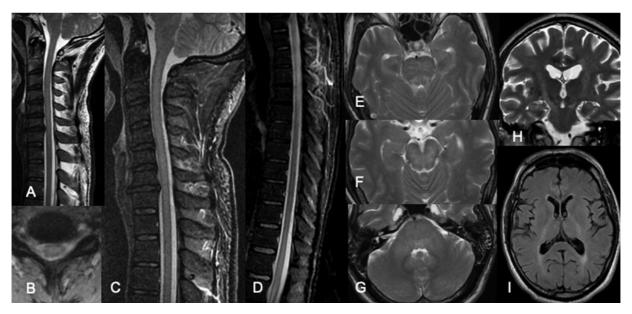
Cervical spinal cord sagittal T2 (A) shows extensive continuous high signal intensity lesion affecting the hole diameter of the spinal cord on axial T2* images (B), best identified on sagittal STIR (C). The extent of more than 3 vertebral bodies was confirmed, as well as the involvement of the medullary cone on sagittal STIR (D). Brain lesions were mainly detected affecting the brain stem on axial T2 images, including the posterior aspect of the mesencephalon (E), pons (F), and the medial cerebellar peduncle (G). Two years follow up brain images show hypersignal intensity on coronal T2 (H) and axial FLAIR (I) images located in the cortical-spinal tract, mostly associated with retrograde degeneration within the spinal cord lesions.
